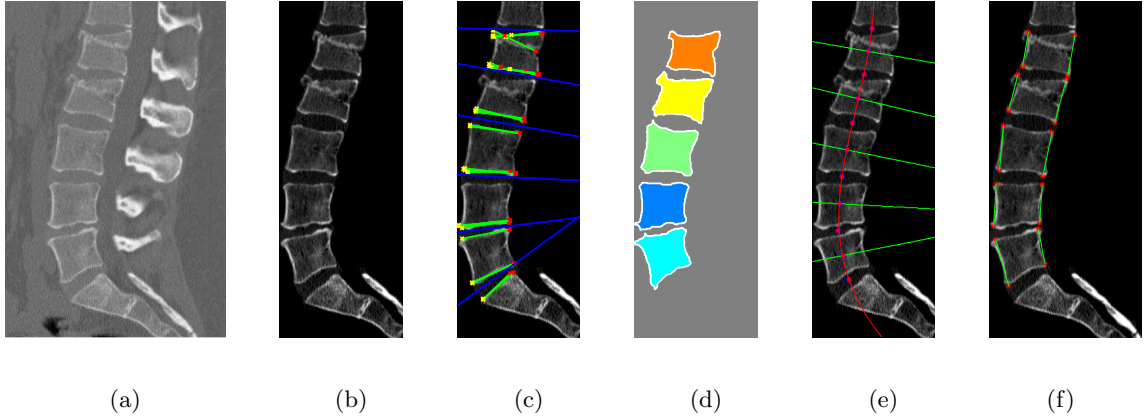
Fully automated processing steps for a case with vertebral fracture at L1 and L2: (a) shows the original CT scan, (b) shows the extracted ROI, (c) shows the Hough Lines in green and the vertebra separating lines in blue, (d) shows the segmented and labelled vertebrae, (e) shows the vertebral centerline in red and orientation of each vertebra in green, (f) shows the automatically detected vertebral corners in red and the left and right vertebra height in green.
